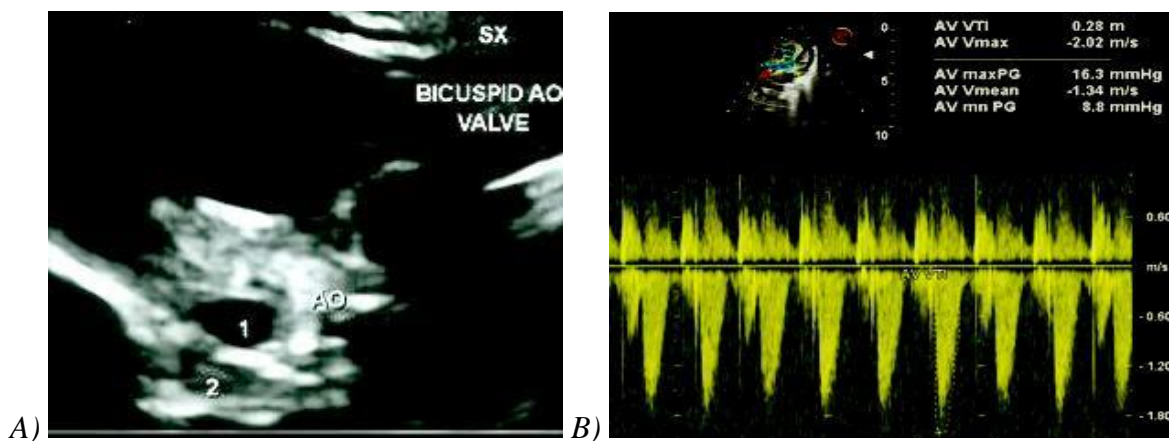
Bicuspid aortic valve stenosis (mild). A) Short axis view at the level of aortic valve shows a bicuspid aortic valve. B) On continuous wave doppler analysis across the aortic valve discovered a peak and mean gradient of 16.3/8.8 mmhg, consistent with mild aortic stenosis.
